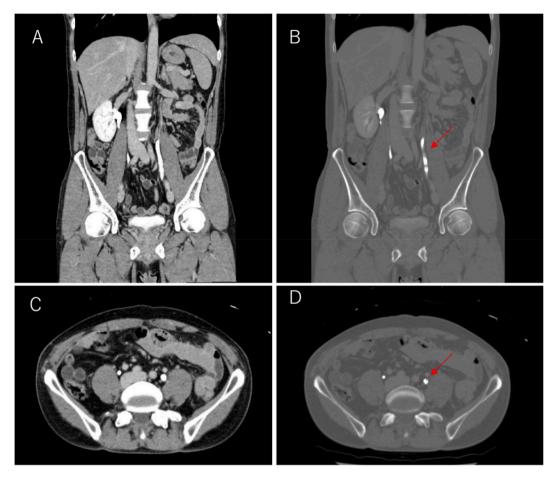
Contrast-enhanced computed tomography (CT) findings. The shadow-deficit area in the left ureter cannot be visualized by CT urography, but it can be visualized after adjusting the contrast (A, B) Coronal sections. (C, D) Axial sections.
